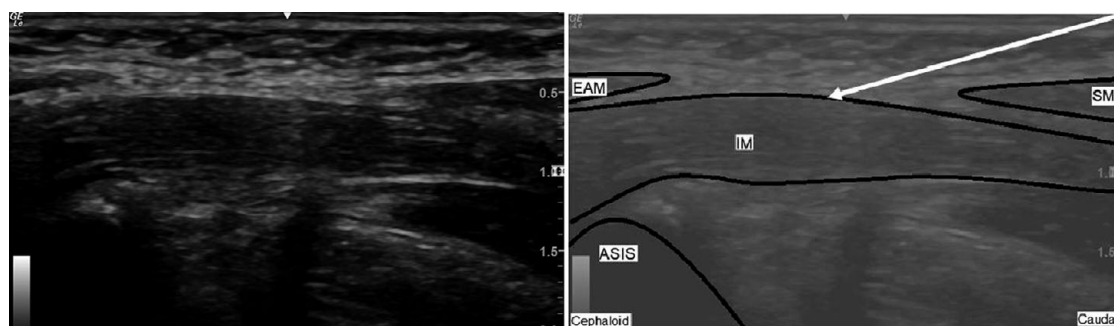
Ultrasound appearance of the fascia iliaca overlying the iliacus muscle (IM), the external abdominal oblique muscle (EAM), sartorius muscle (SM) and the anterior superior iliac spine (ASIS).
